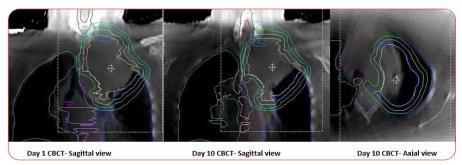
Reduction of clinical tumour visible from day 1 to day 10 on CBCT.
